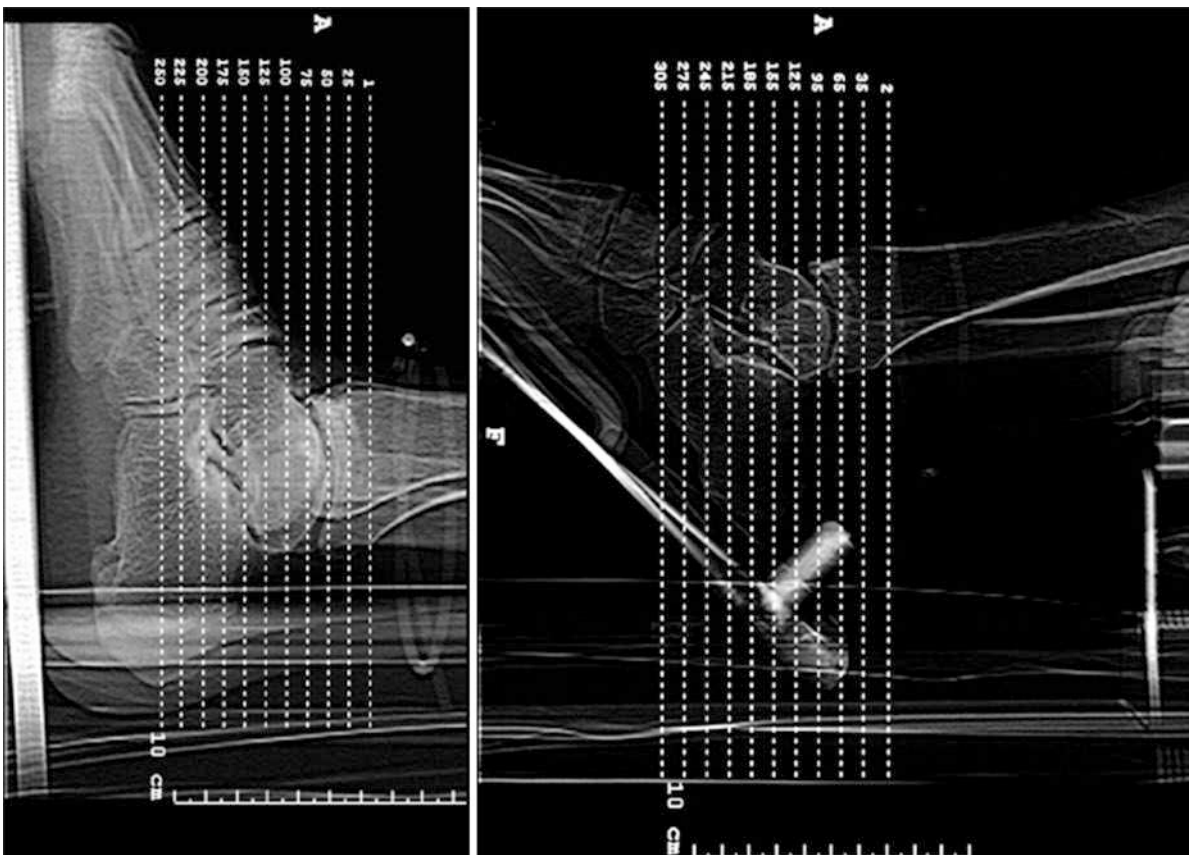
Scout views of the general CT in dorsiflexion and the CT in maximal plantar flexion
